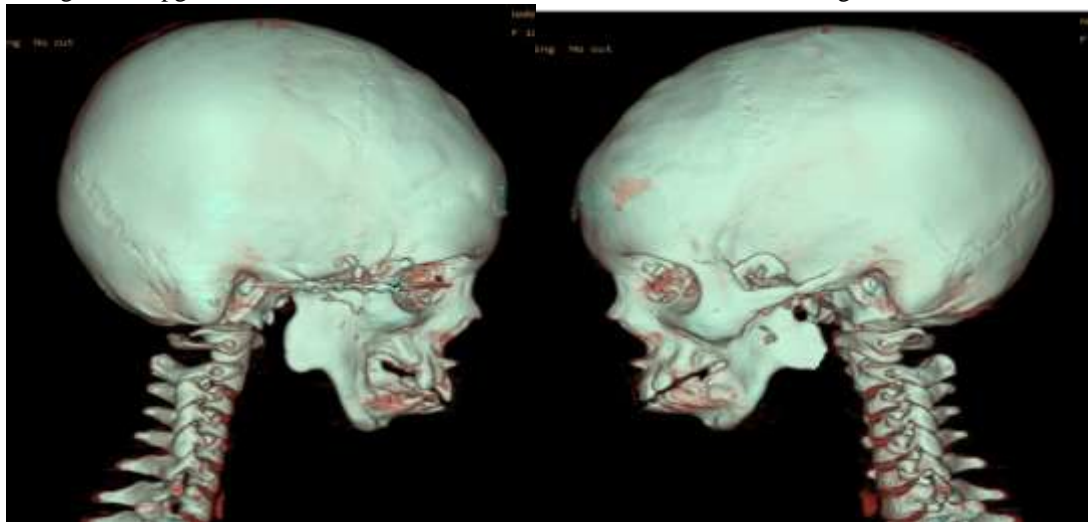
right lateral 3D CT
